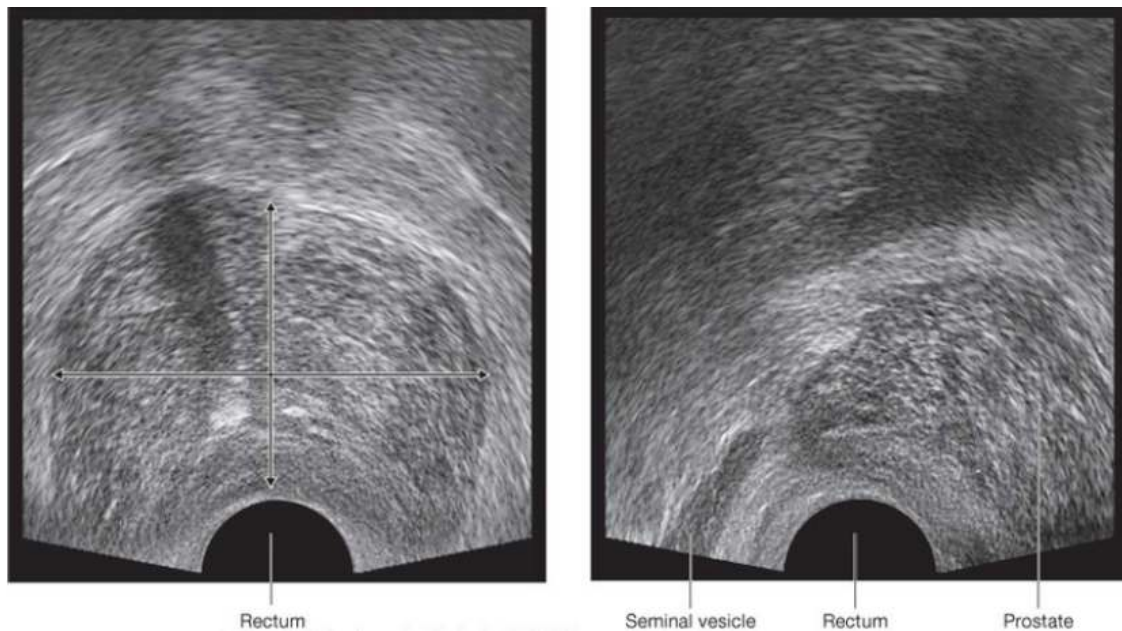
Rectal ultrasound imaging of the clinically normal prostate. A) Transverse view. Boundaries of the prostate are indicated by arrows. B) Sagittal view. Seminal vesicle also visible.(Drake et al, 2009)
